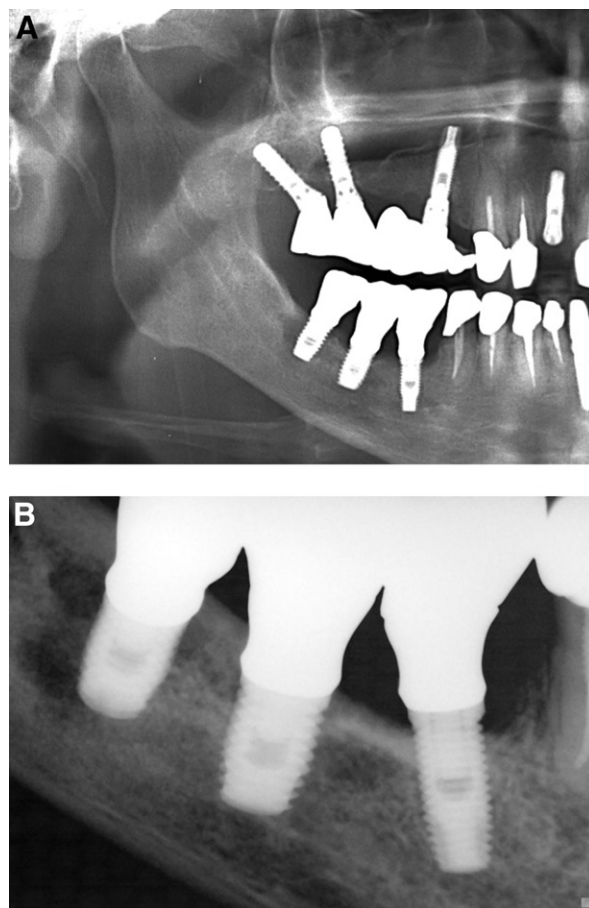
Radiographic examination 13 years after the placement of the implant. A, A panoramic radiograph shows that loss of bone occurred in a wide range owing to the peri-implantitis that occurred around the implant in the right mandibular second molar area. It shows that the loss of bone is particularly severe in the area around the fixture. B, Periapical radiograph shows that the radiolucent area has extended to the apex of the implant.
